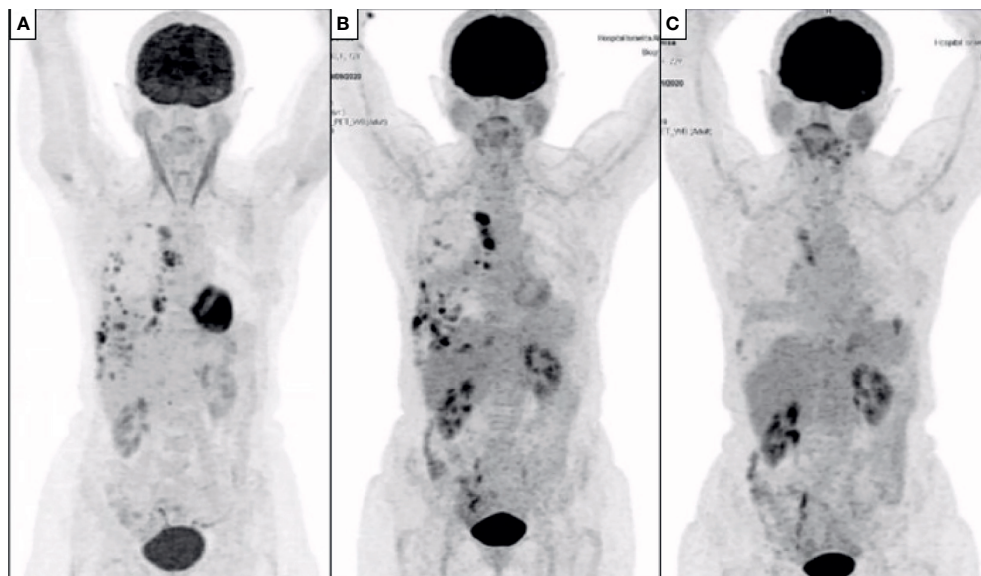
PET-CT at baseline and during treatment. (A) Baseline PET-CT demonstrating right pleural implants and mediastinal lymph node involvement; (B) restaging PET-CT after 2 cycles of treatment showing improvement in pleural nodules, but enlargement of lymph nodes; (C) PET-CT after 4 cycles showing complete improvement in pleural implants, and near-complete improvement of lymph nodes.
